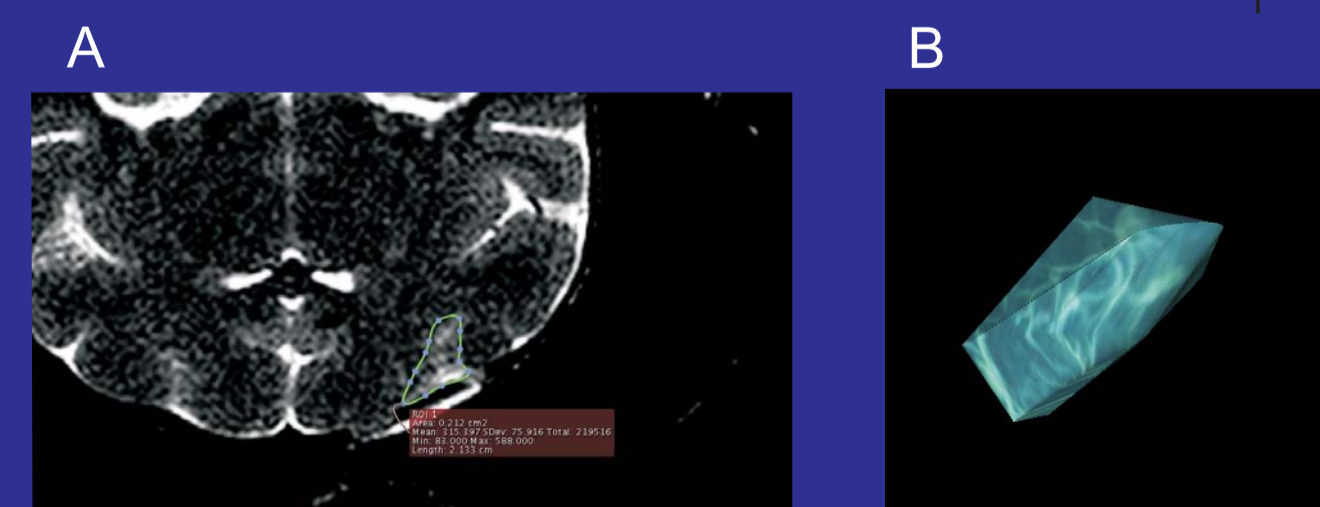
MRI with delimitation of lesion (A) to obtain volume (B) performed in Mk-CB 22 D post lesions
